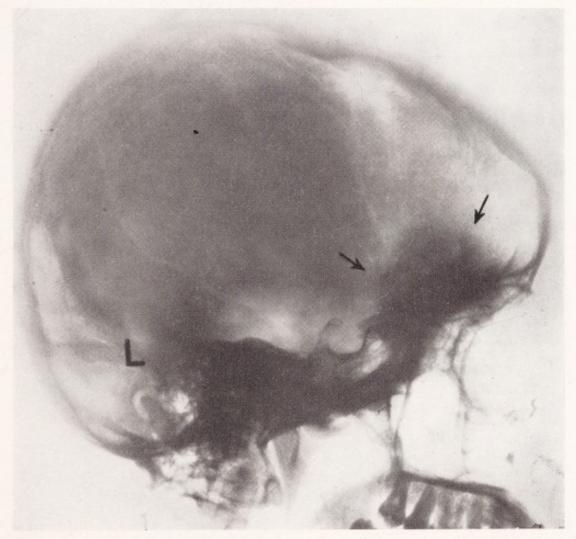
Case 19. X-ray showing marked hyperostosis of skull and roof of orbit.
